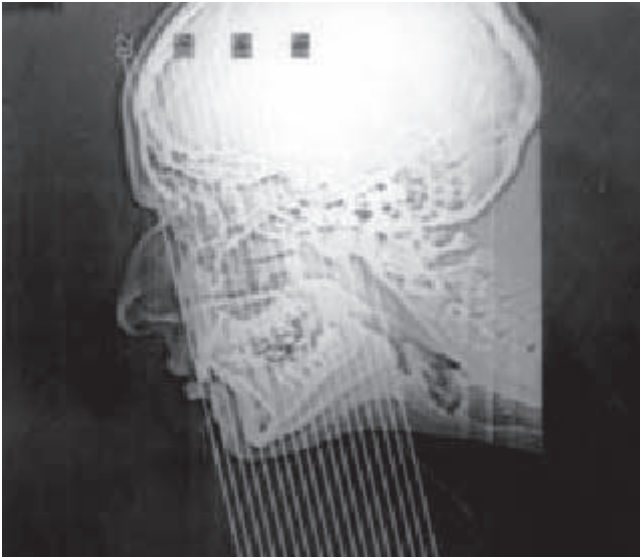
Coronal CT scanning of the nasal cavity.
